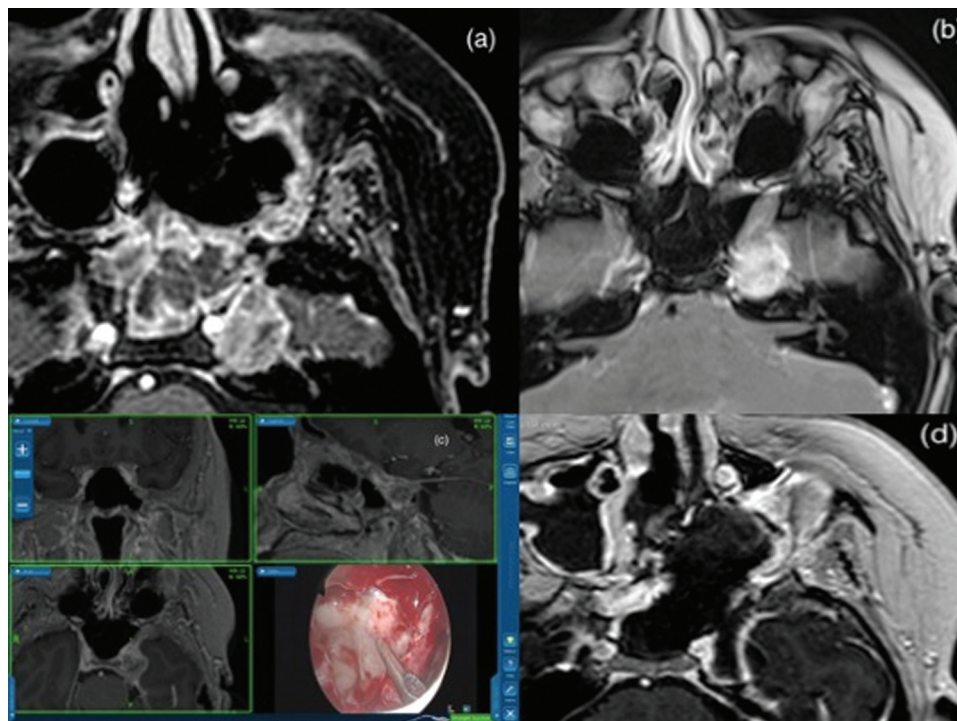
Case 3: (a) and (b) Preoperative axial gadolinium-enhanced T1-weighted MRI showing an ACC infiltrating the left cavernous sinus and Meckel's cave with extension to the corresponding pterygopalatine fossa. (c) Intraoperative neuronavigation images of the endoscopic transsphenoidal approach. Suction tip points out the projection of the tumor to the lateral wall of the sphenoid sinus. (d) Postoperative image showing the near total removal of the tumor. ACC, adenoid cystic carcinoma; MRI, magnetic resonance imaging.
